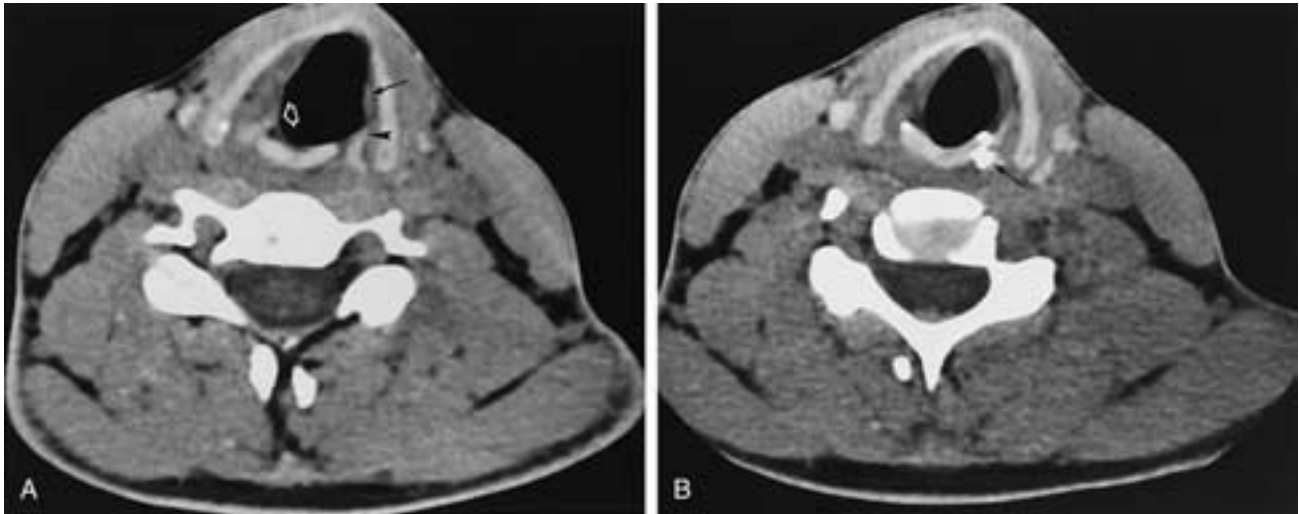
Axial CT. A, Adductor paralysis. Left side shows almost no TAM (*arrow*). The vocal process (*arrowhead*) is pulled laterally as the posterior cricoarytenoid muscle rotates the arytenoid laterally and posteriorly. Compare the position of the vocal process on the normal side (*open arrow*). B, Slightly lower scan shows a portion of the arytenoid pulled posteriorly and downward (*arrow*), overlapping the posterior surface of the cricoid.
